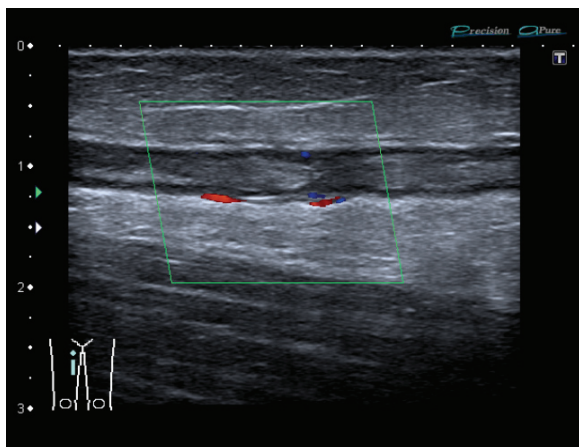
Doppler ultrasound of the right leg showing venous thrombosis in the superficial femoral vein (A, left) and great saphenous (B, right) vein of the right thigh
